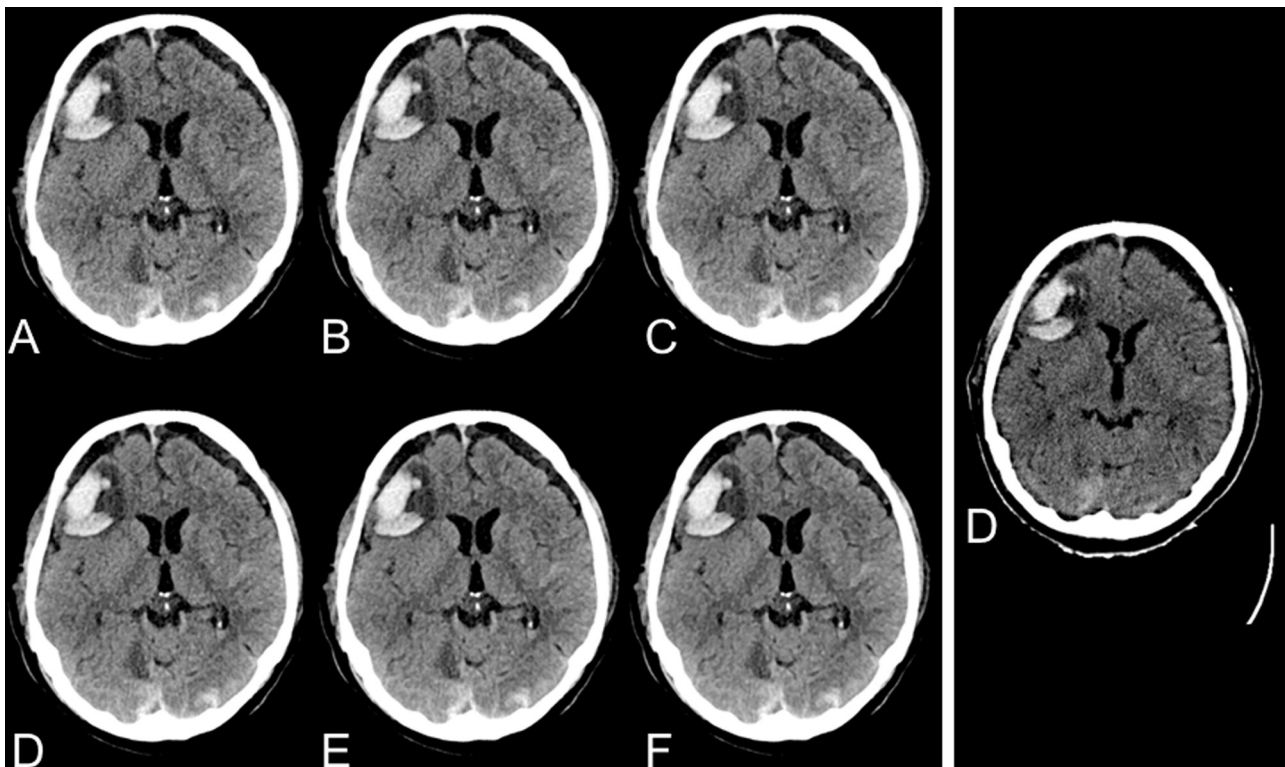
Cranial CT of a 69-year-old male patient after traumatic brain injury and consecutive intracerebral hemorrhage contusion as well as chronic bilateral subdural hemorrhage. Intra-individual comparison of spiral DSCT at 5 different IR strength levels (A = FBP, B = IR 1, C = IR 3, D = IR 4, E = IR 5) and sequential MDCT using FBP (D).
